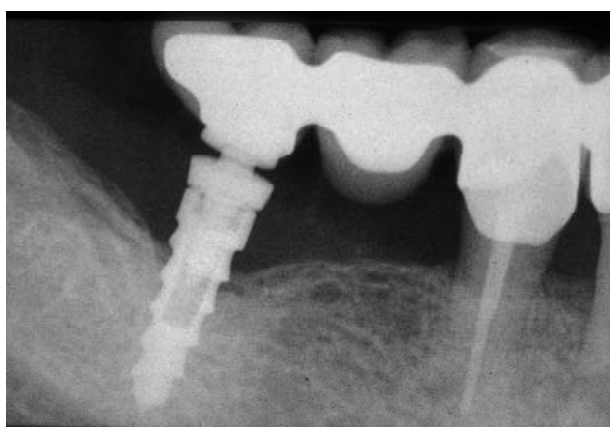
At 4 years following treatment with EMD some defect fill can be observed on the intraoral radiograph (case 3 from Table 1).
